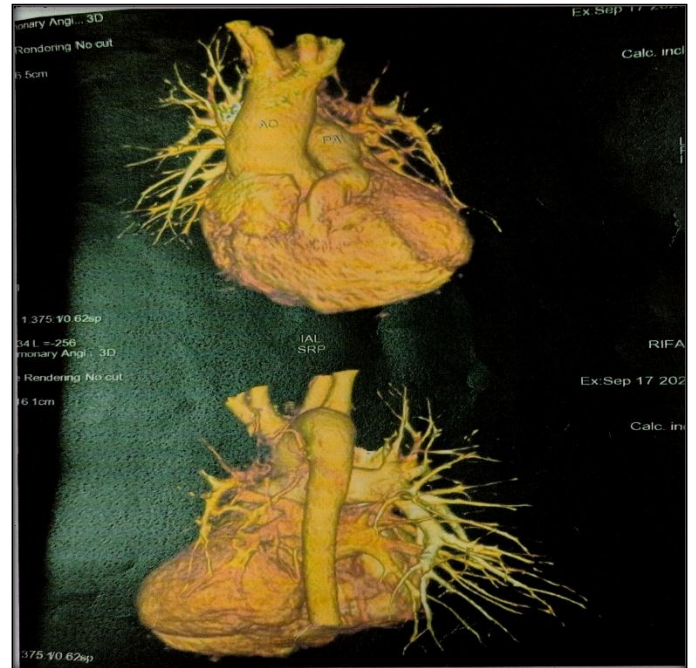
CT angiogram of heart and great vessels showing absent left pulmonary artery.
